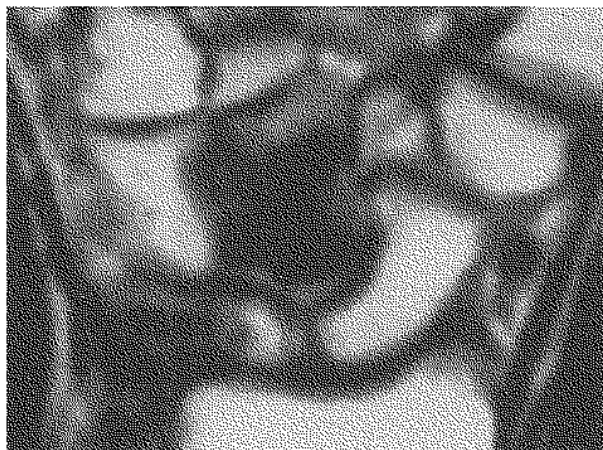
Preoperative magnetic resonance image showing the black-hole sign characteristic of avascular necrosis of the capitate bone.
